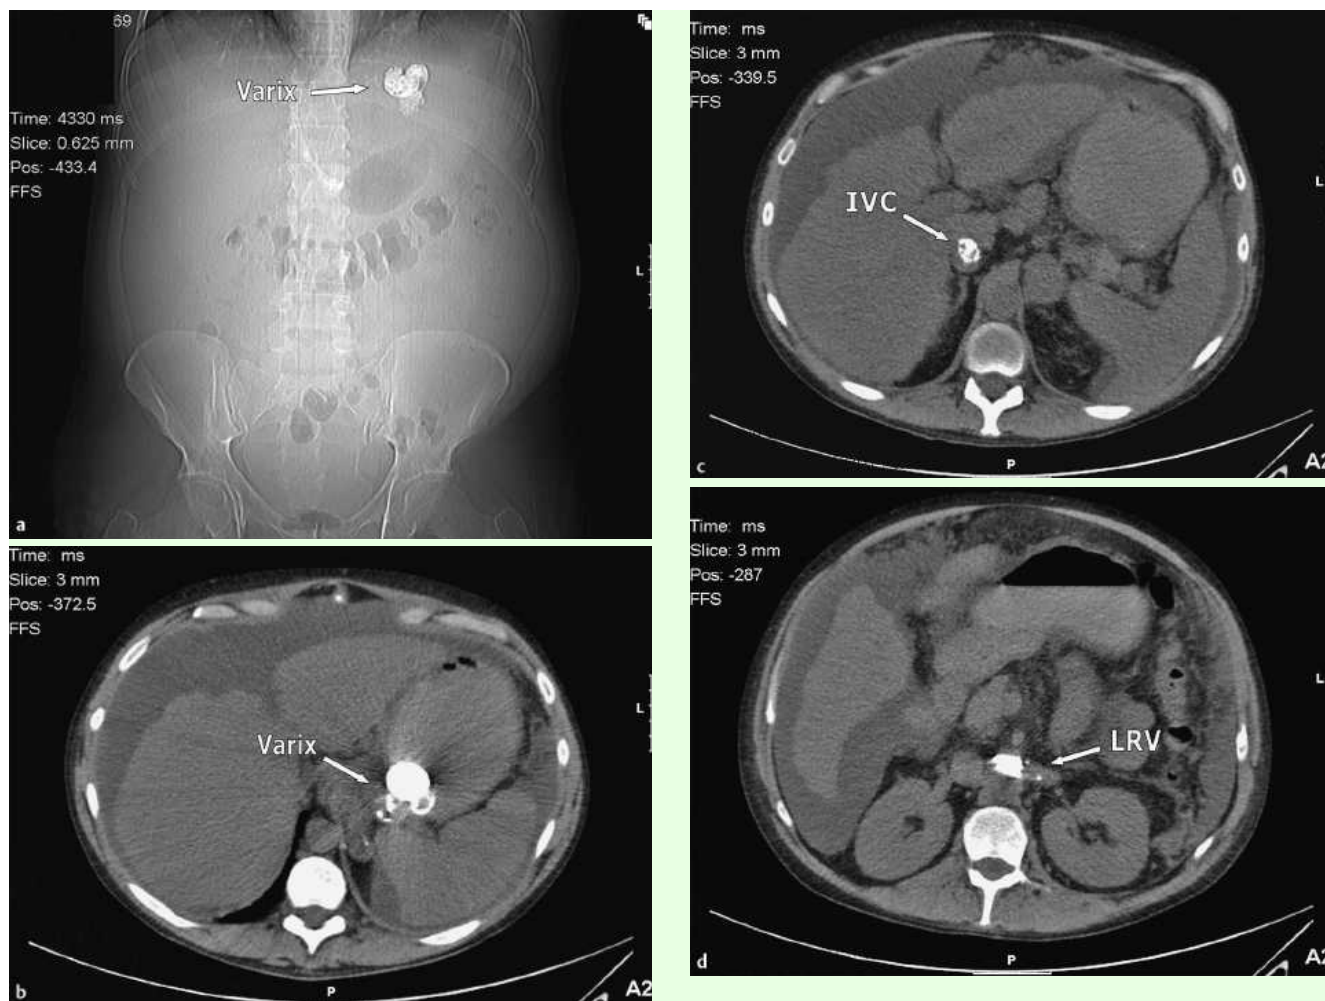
a–d Abdominal/pelvic CT scan showing multifocal radiopaque densities in the gastric fundal varix and also inferior vena cava (IVC) extending to the left renal vein (LRV) consistent with retained systemically embolized glue, within days of repeated endoscopic injections of glue/lipiodol for gastric variceal hemorrhage.
